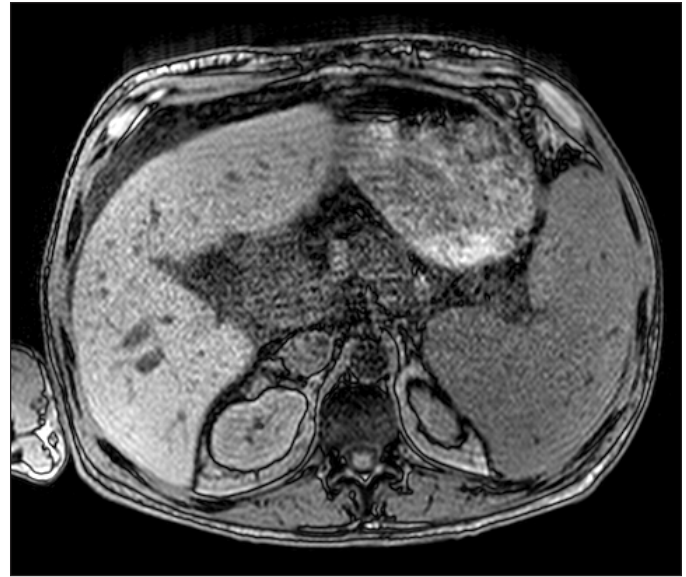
Abdominal MRI showing splenomegaly.
